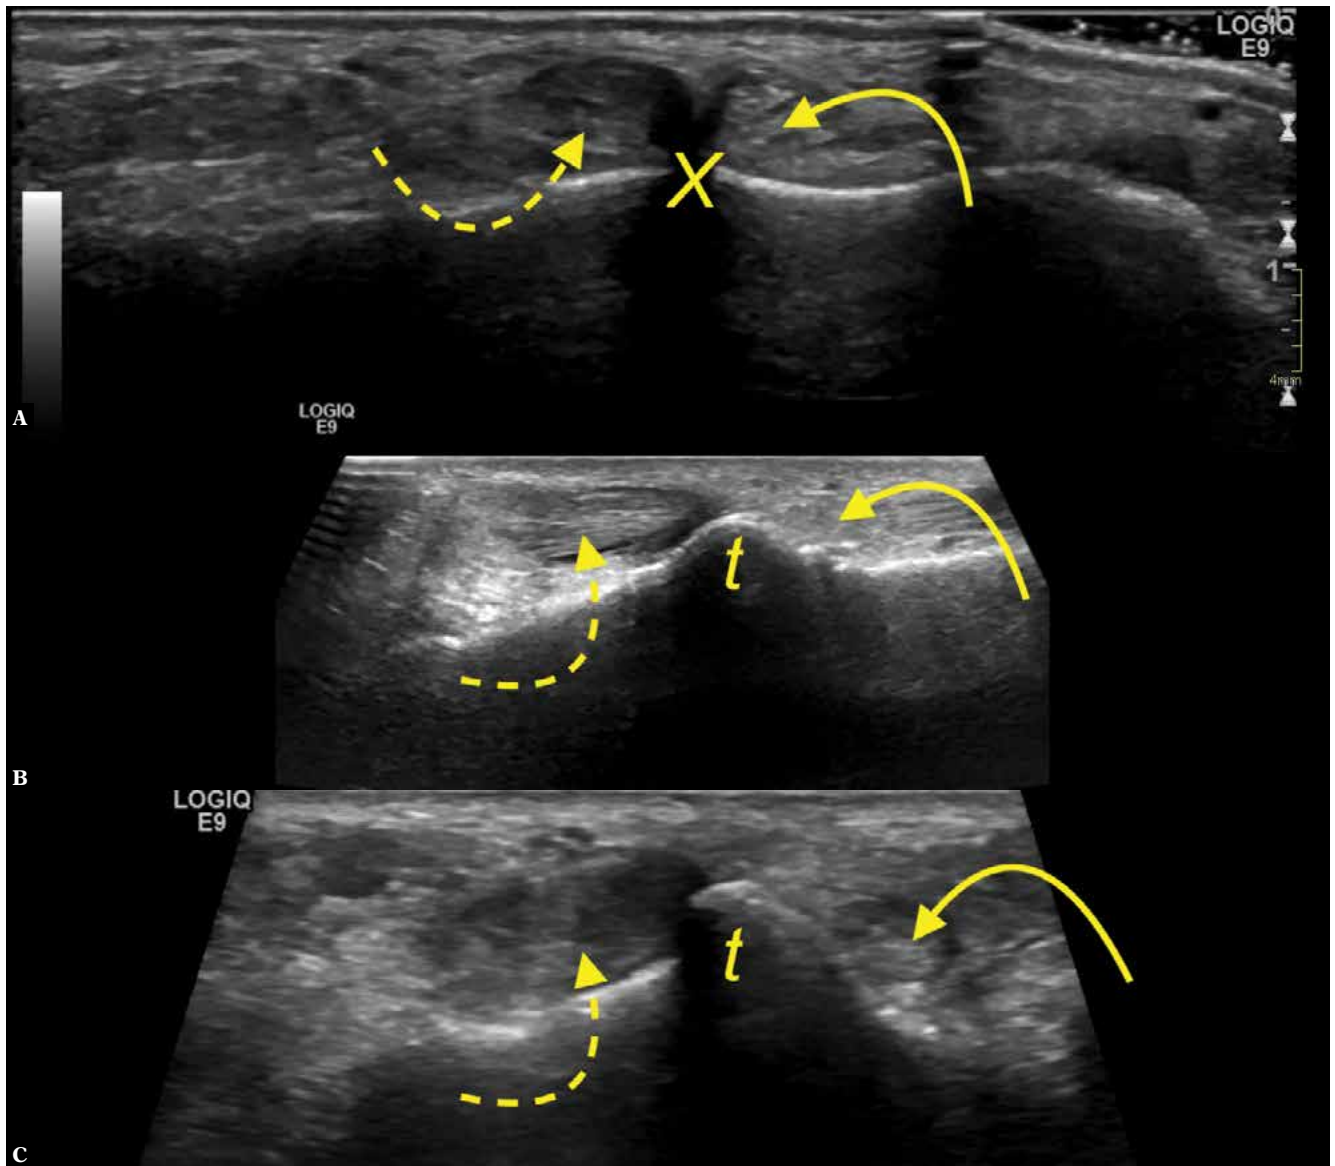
Anatomical variations of the peroneal tubercle, three different patients. A, B, C. coronal sections, ultrasound, A. no explicit peroneal tubercle was noted (X), B, C. the peroneal tubercle (t) was present. The peroneus brevis (curved arrow) and the peroneus longus (dashes curved arrow)
